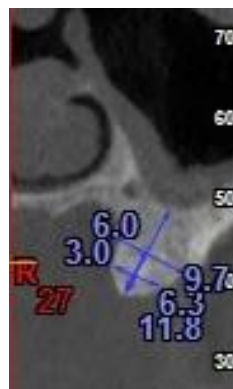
CBCT image shows bone height & Bone width
